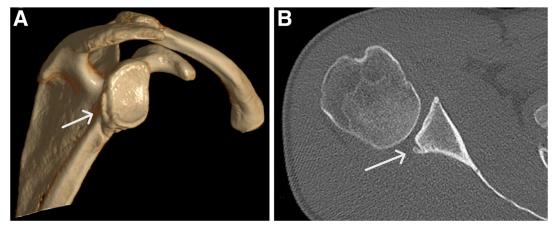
Lateral view of a 3-dimensional computed tomography image of the right scapula (A) and axial (B) view of the same scan. The mis-healed bone fragment (arrows) can be seen at the posterior part of the glenoid.
